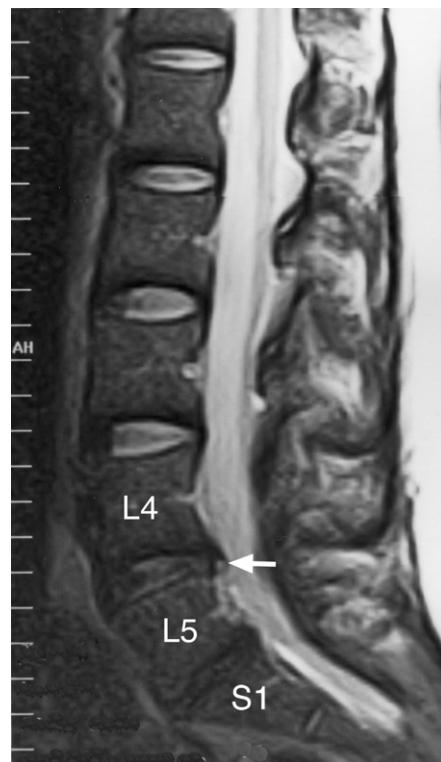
Lumbar spine MRI sagittal T2-weighted image showing loss of signal at the L4–5 and L5–S1 intervertebral disc levels in keeping with disc desiccation. There are minimal bulges of these discs with adequate spinal canal dimensions. Note the high intensity zone in the posterior bulge of the L4–5 intervertebral disc (arrow).
